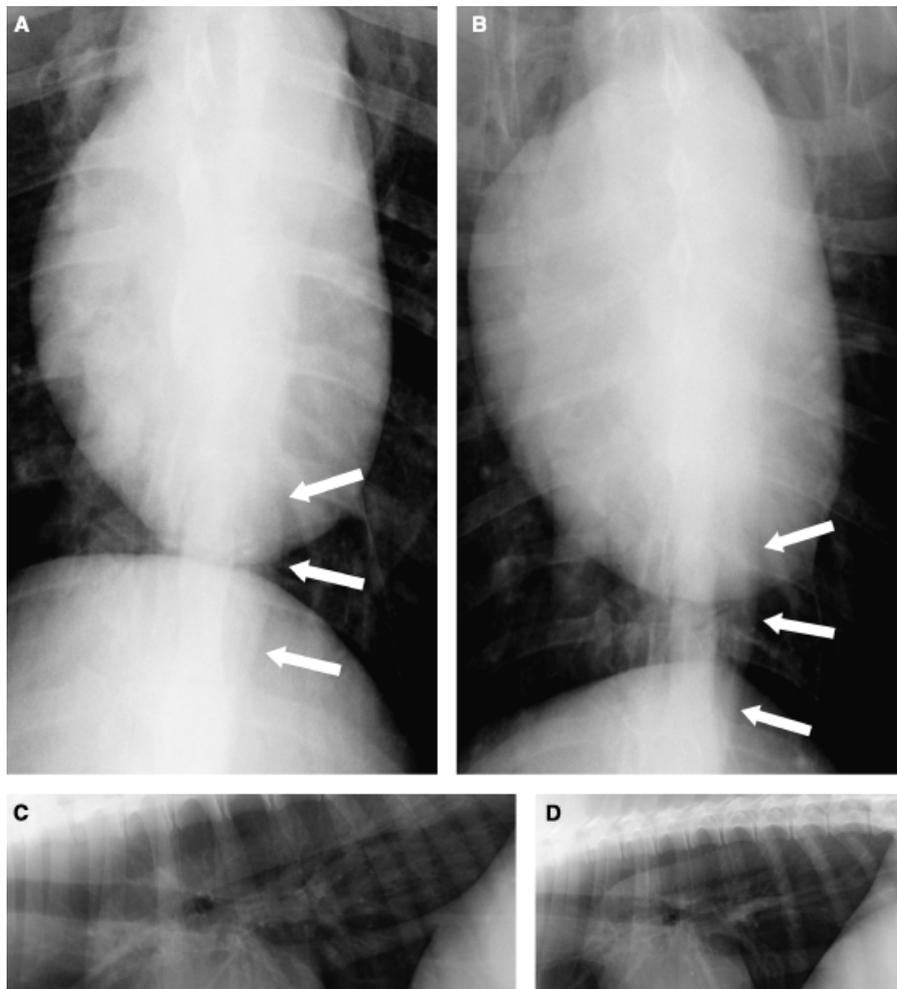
Mid caudal and caudodorsal thoracic radiographs of a 6-year-old Great Dane with spirocercosis. (A) Dorsoventral view with obvious lesion superimposed on caudal cardiac and diaphragmatic silhouettes. (B) Ventrodorsal view with similar lesion. (C) Right lateral recumbent and (D) left lateral recumbent views with no caudodorsal mediastinal mass visible.
